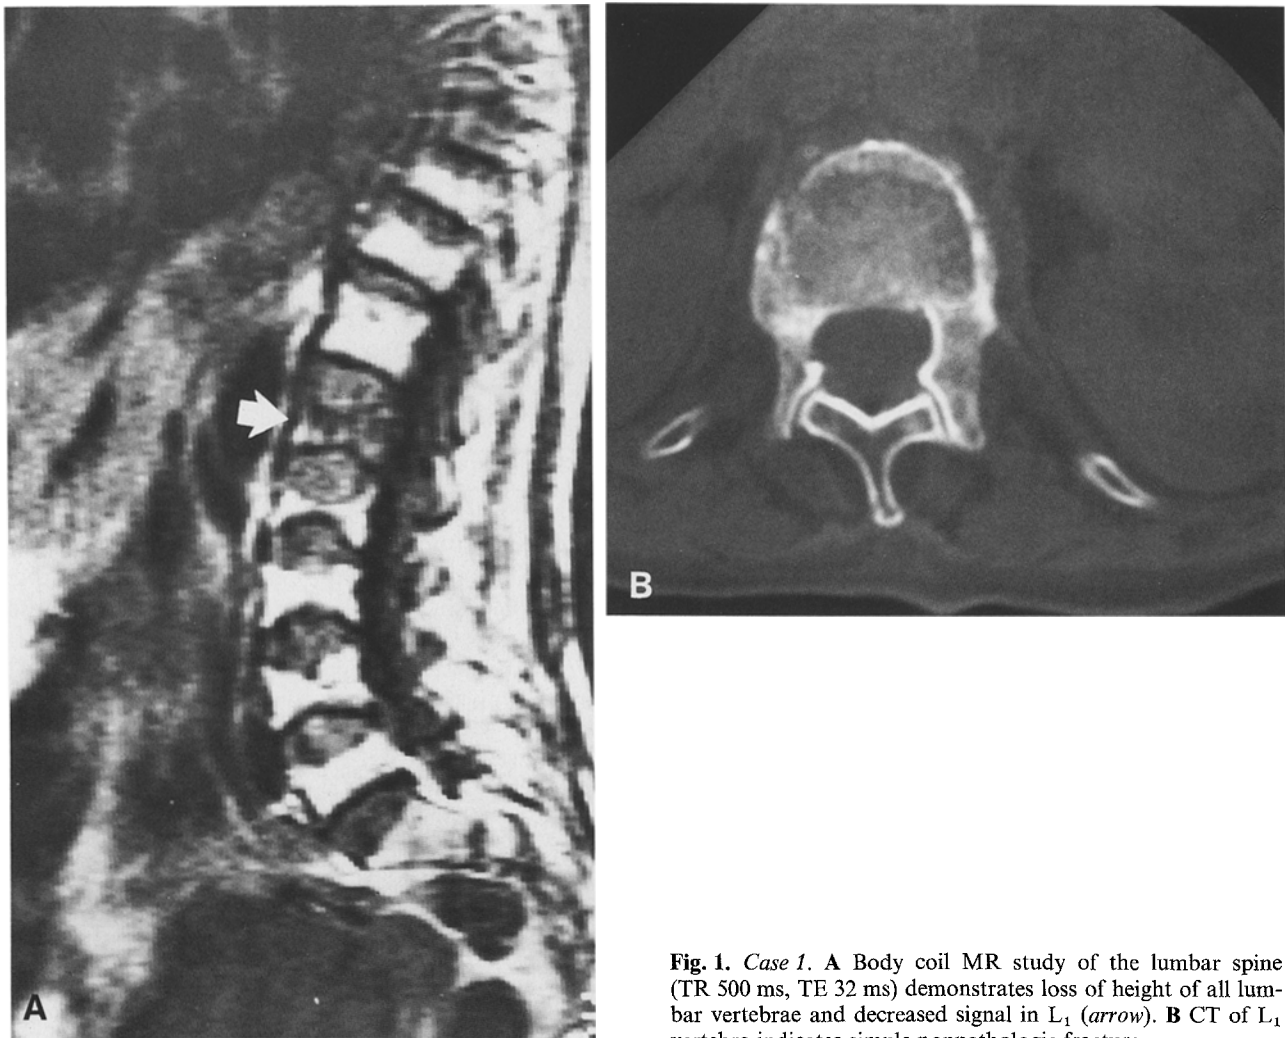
Case 1. A Body coil MR study of the lumbar spine (TR 500 ms, TE 32 ms) demonstrates loss of height of all lumbar vertebrae and decreased signal in L₁ (arrow). B CT of L₁ vertebra indicates simple nonpathologic fracture
